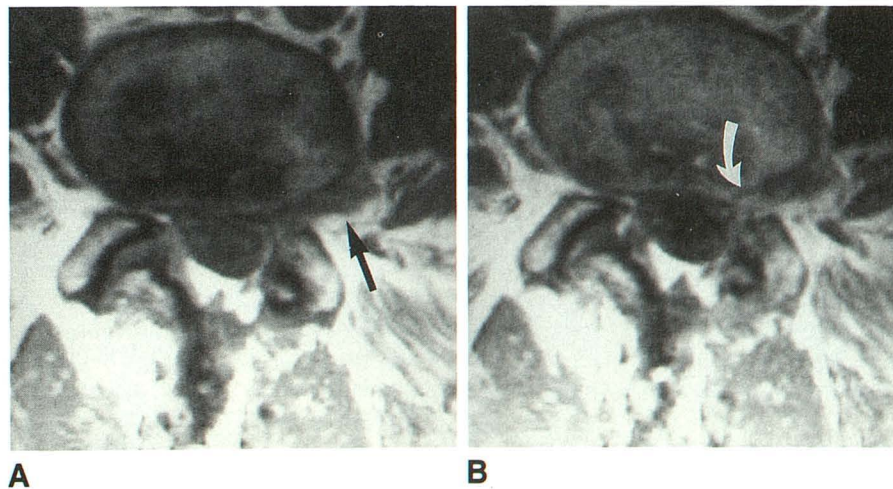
A, Axial T1-weighted (500/17) pre-contrast MR image at L4-L5 shows an apparent left lateral disk herniation (arrow).
